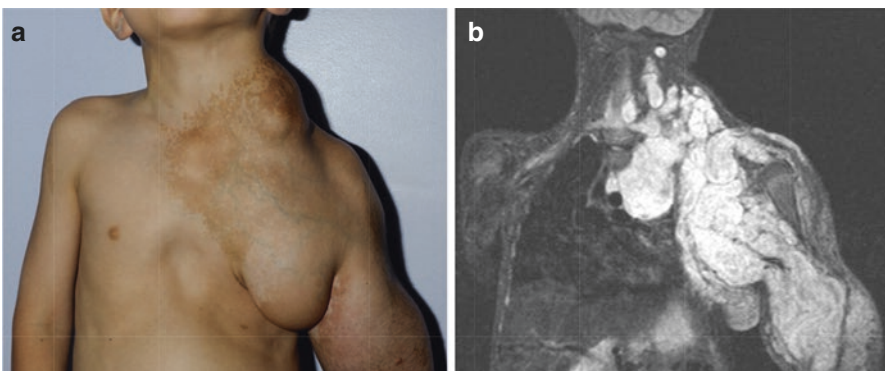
Plexiform neurofibroma in a pediatric patient with NF1. (a) Clinical appearance, (b) MRI study [10] (Dagalakis et al. 2014; reprinted with permission from Elsevier, UK.) This case represents a typical example of superimposed mosaic NF1
